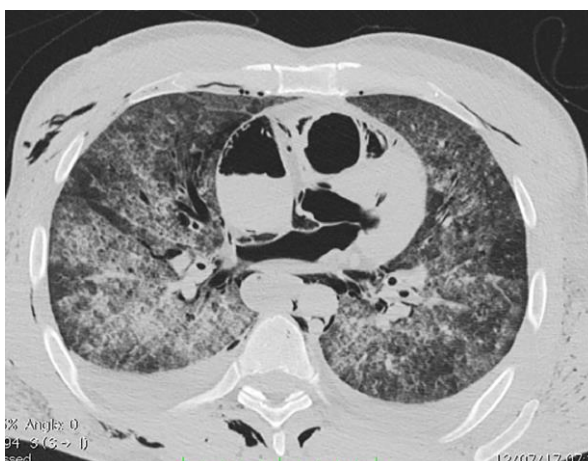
Axial PMCT at thorax level used in a case of suspected drowning. Figure reprinted with permission from Filograna L, Pugliese L, Muto M, Tatulli D, Guglielmi G, Thali MJ, Floris R (2019) A Practical Guide to Virtual Autopsy: Why, When and How. *Semin Ultrasound CT MR* 40 (1):56-66. doi:10.1053/j.sult.2018.10.011 [2]
